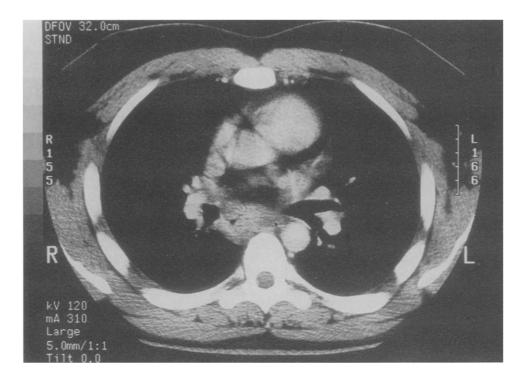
Contrast-enhanced computed tomography demonstrates a 3×4 cm subcarinal mass, marked narrowing of esophageal lumen, and deformity of medial wall of bronchus intermedius.
